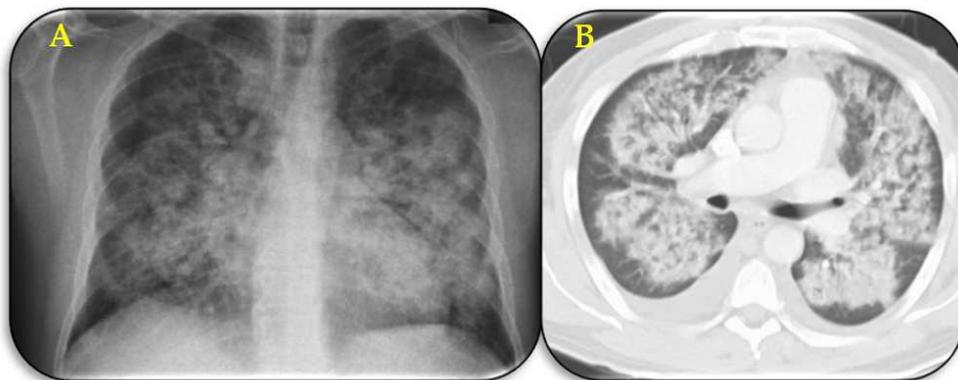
Male patient 47 years of age diagnosed with H1N1 and 15 days earlier. A) The radiograph shows bilateral alveolar opacities; B) TAC Atypical pneumonia, and diffuse alveolar damage.
